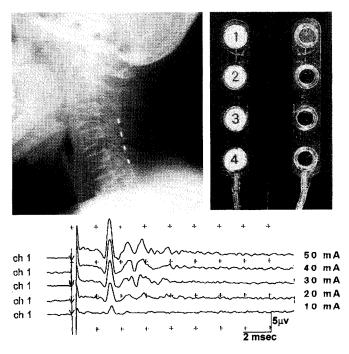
Upper left: Radiograph showing a 4-channel wire electrode placed within the epidural space of the C3–C4 cervical spinal cord. Upper right: Multicontact plate electrode for direct cortical stimulation. The device has four contact points, and each plate electrode is 5 mm in diameter and spaced 5 mm apart. Lower: Cortico-spinal MEP recordings. The stimulation intensity was increased from 10 mA to 50 mA. (Time scale, 2 ms; amplitude, 5 μ V)
